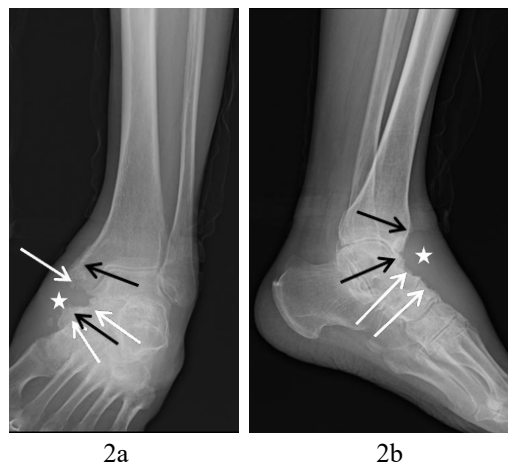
Radiographic images of Mycetoma. FINDINGS: anterior posterior (AP) (2a) and lateral position (2b) radiographs demonstrate soft tissue swelling (asterisk), bone erosion (white arrow), sclerosis, periosteal reaction (black arrow) and osteoporosis. TECHNIQUE: AP and lateral position radiographs, 10mAs, 65kV.
